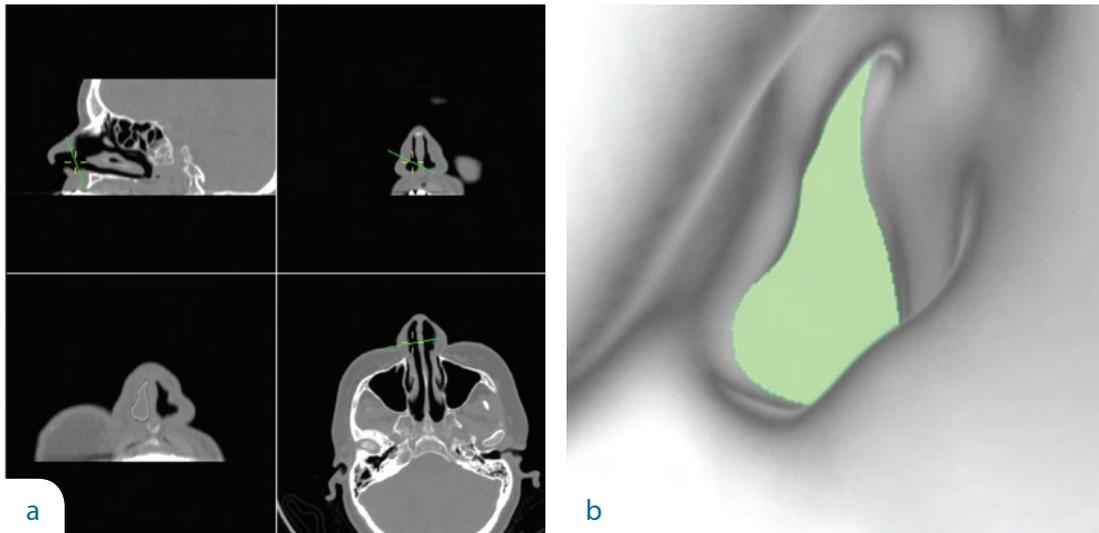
Example of how the computer software determines and presents an oblique plane on CT. The yellow cross-hair indicates the selected location corresponding in all three views. The green line indicates the intersection of the oblique slice plane with the orthogonal views. Top-left shows the sagittal slice plane, top-right the coronal plane and bottom-right the axial plane. Bottom-left shows the oblique slice plane with the determined area of the nasal passage in white.
